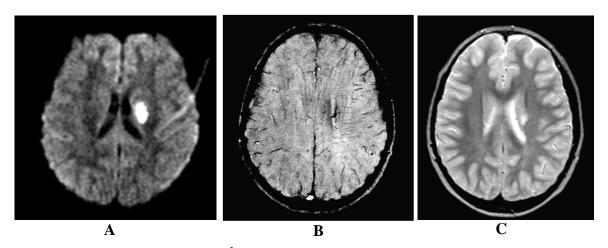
High resolution (1.0 mm³) SWI comparison to conventional MRI in the brain. A. Conventional DWI image showing an infarct in the caudate nucleus. B. The SWI scan showing the potential tissue at risk on the left side related to circulation associated with the left caudate nucleus. The enhancement of the small vessels at this short TE is out of the norm and indicative of a change in local oxygen saturation or local blood volume. C. A conventional T2 weighted image showing edema in the same region. This increased sensitivity to deoxygenated blood and blood products is evident. With SWI, MRI has the potential one day to become the gold standard for the determination of location of stroke and whether or not any bleeding has occurred.
